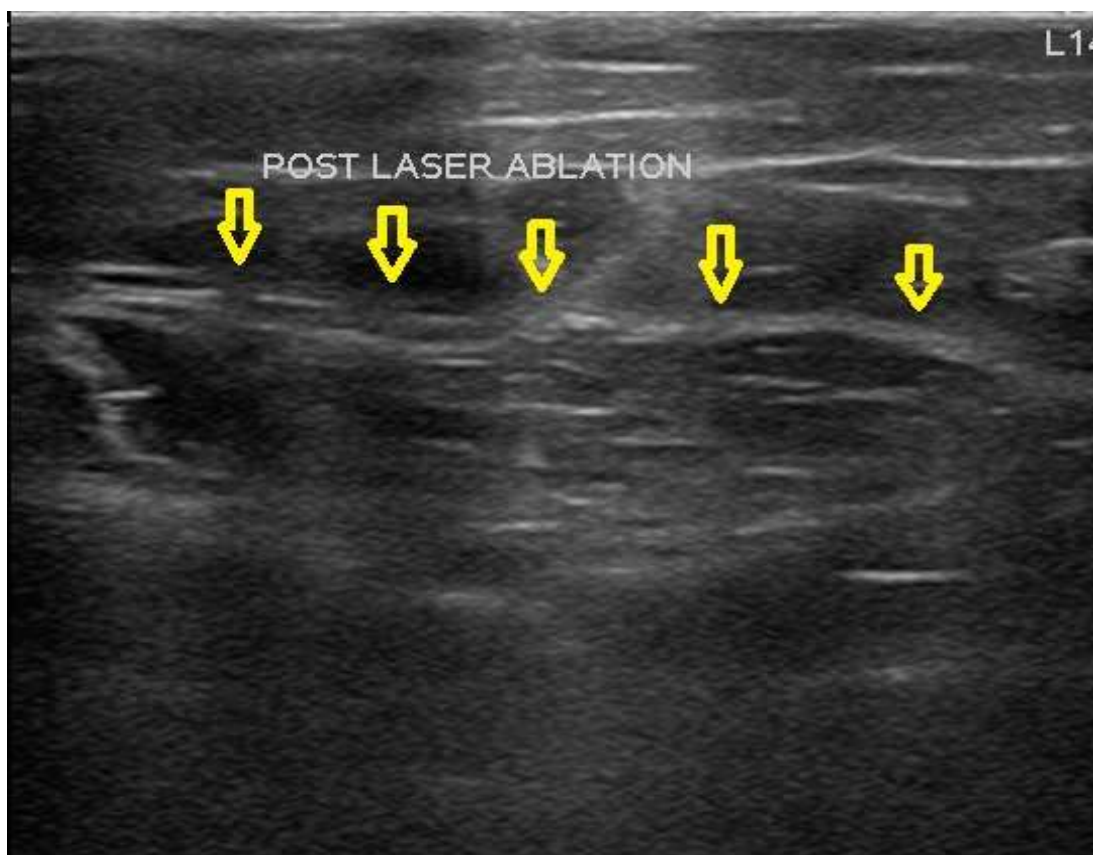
Ultrasound done after 6 months follow up revealed nearly obliterated lumen of the GSV.
